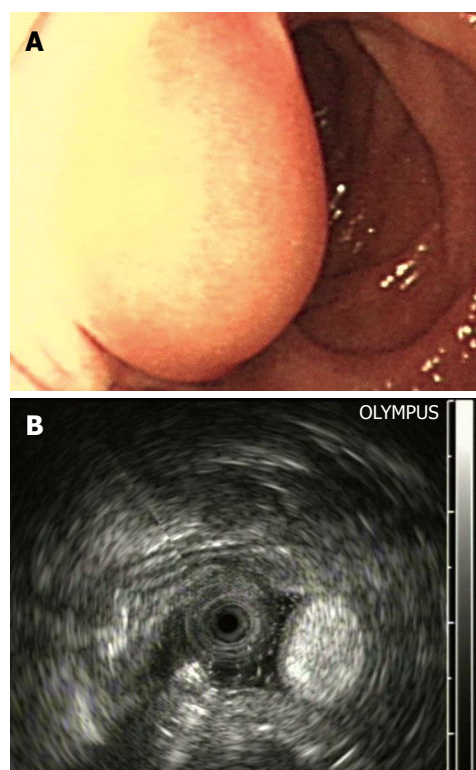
Endoscopic and endoscopic ultrasonography findings in Case 8. A: A lobulated submucosal tumor in the descendant duodenum with an ulcer on its surface; B: Endoscopic ultrasonography showed an intensive hyperechoic lesion with a distinct anterior border originating from the submucosal layer without involvement of the overlying mucosal layer. The posterior border of the tumor was invisible because of the marked echo-attenuation.
